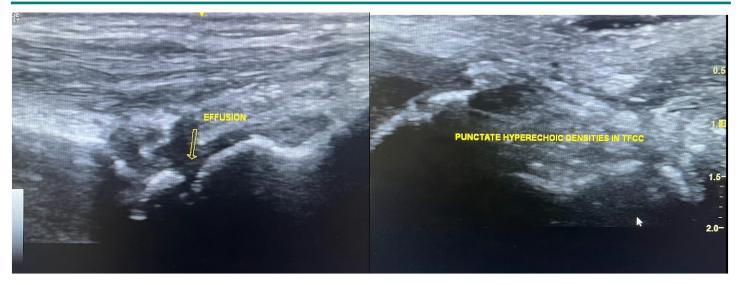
[A] Ultrasound [US] image of the dorsal aspect of the radiocarpal joint showing effusion between the radiolunate joint. [B] US image of the ultra aspect of the wrist shows echogenic foci with punctate calcification in the TFCC.
